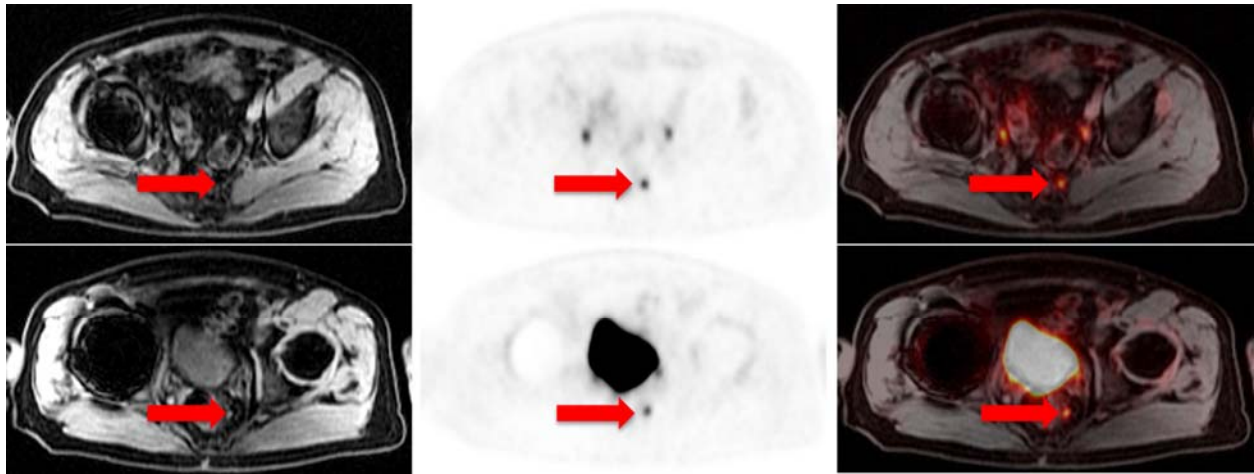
65 year-old man (participant #11) with PCa treated with radical prostatectomy at initial presentation (Gleason 4+3), now with BCR since 2015 and rising PSA (from 0.45 to 2.33 ng/ml at time of the scan). Transaxial ^{68}Ga -RM2 PET images show focal uptake corresponding to sub-5 mm pelvic lymph nodes on MRI (T1w) and fused PET/MRI. PSA decreased to <0.05 ng/ml after pelvic radiation therapy targeting these lymph nodes.
